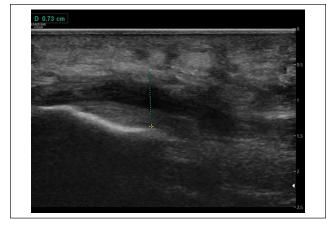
Ultrasonographic imaging of the plantar fascia origin at the calcaneus before the plantar fasciotomy showing the hypoechoic swelling in the fascia and a plantar fascia thickness of 7.3 mm.
